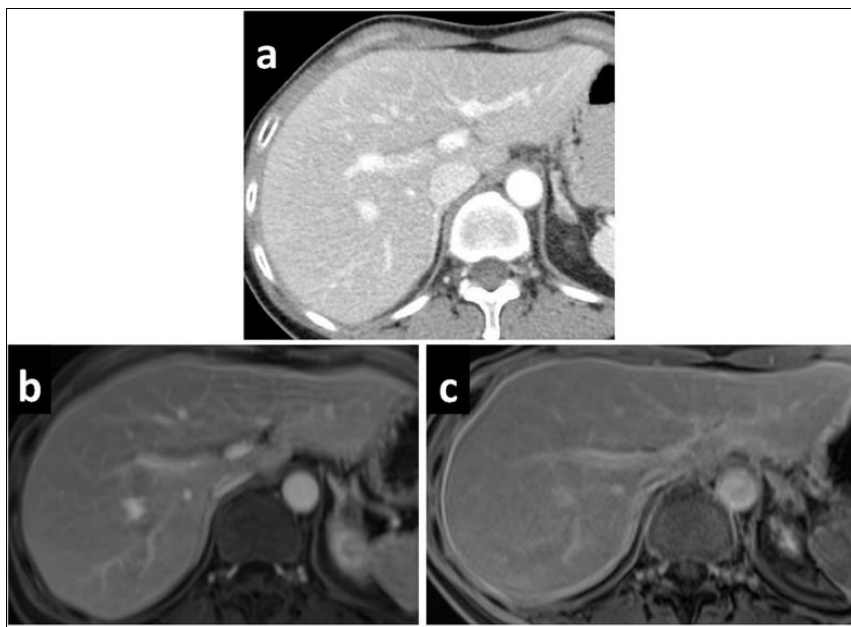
(a) CT reveals no significant abnormality, MRI demonstrates a thin enhancing line surrounding the liver (b) portal venous phase, which becomes more apparent on the (c) delayed phase
